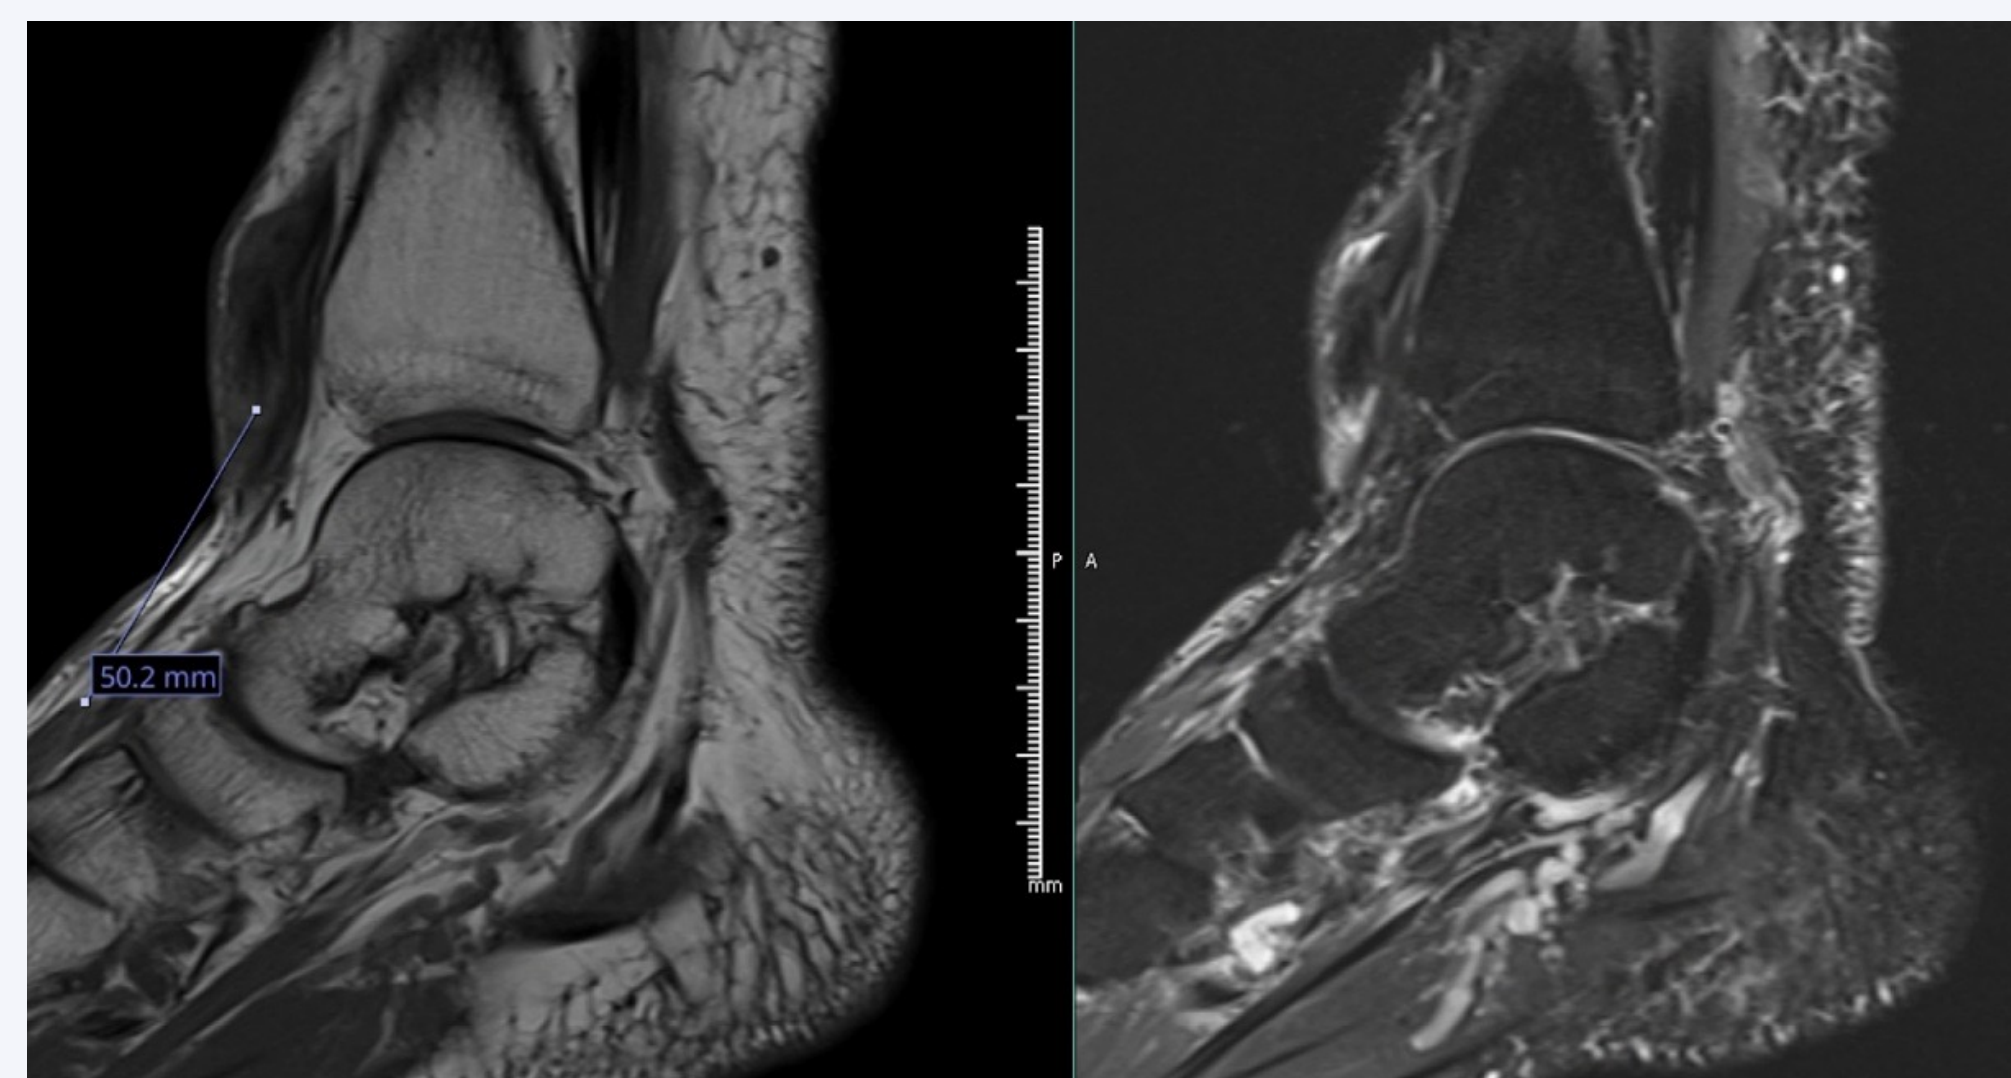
T1 (left) and T2 (right) Sagittal MRI imaging of a high-grade tear of the TA tendon with ~6cm deficit. Significant retraction and tendinosis were noted of the proximal TA tendon stump.
